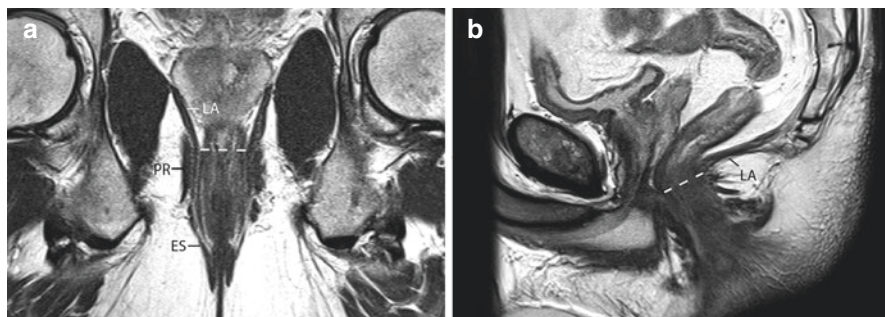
Normal anatomy on oblique coronal (a) and sagittal (b) T2-weighted sequences, pointed out are the external sphincter (ES), puborectal muscle (PR), and levator ani muscle (LA). The white dashed line represents the anorectal junction, at the transition of the superior border of the puborectal muscle to the levator ani muscle
